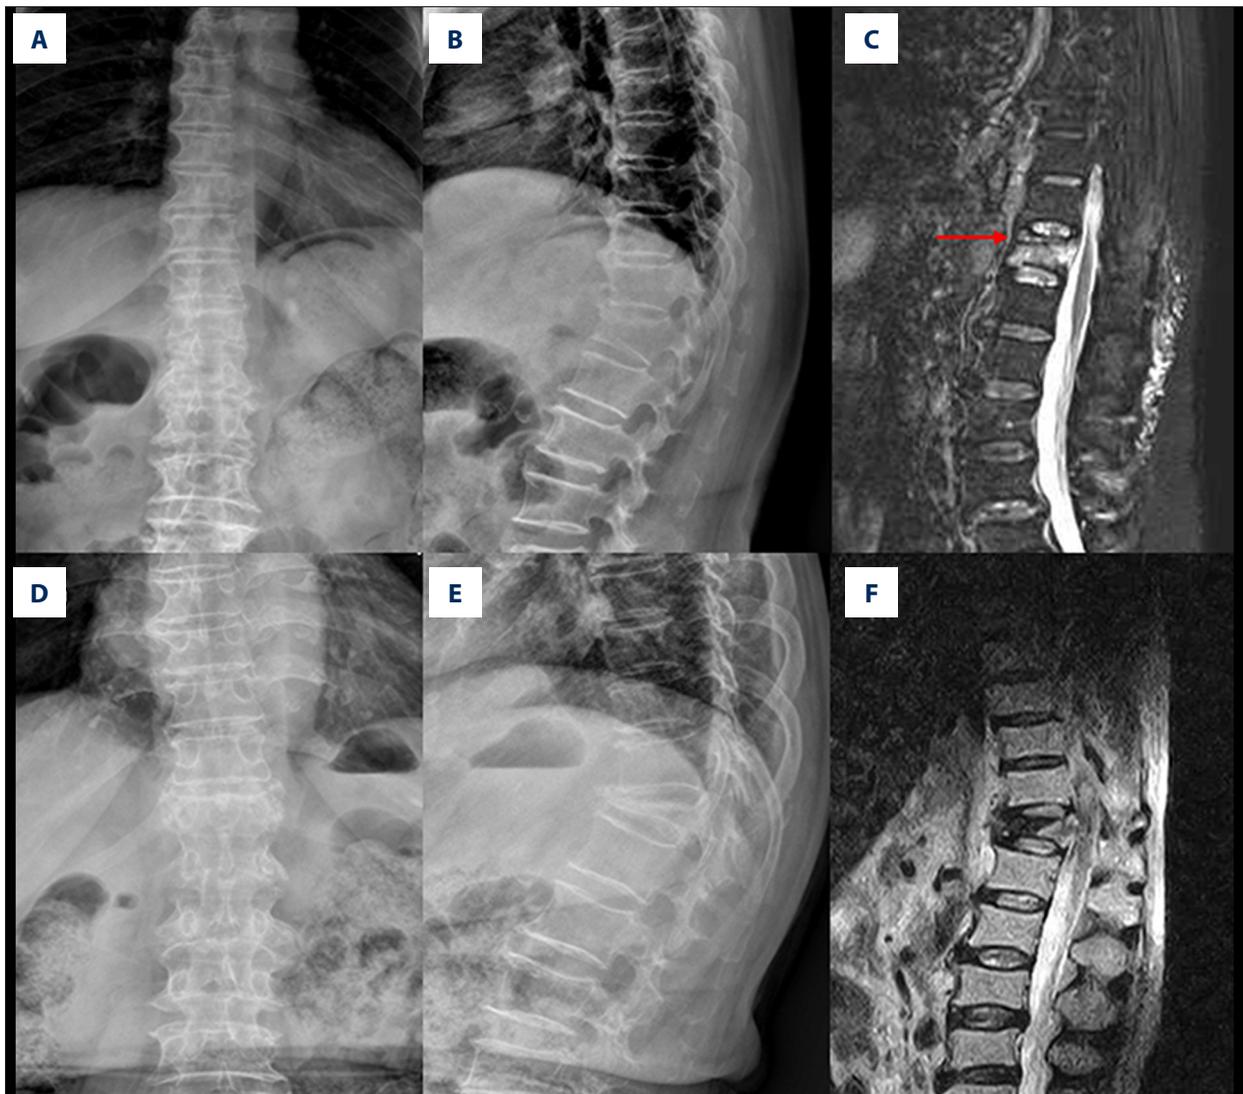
A 72-year-old female patient had a L1 osteoporotic vertebral compression fracture as a result of a fall. (A, B) X-ray showed L1 vertebral compression fracture. (C) A linear black signal was detected on MRI STIR sequence (red arrow). (D, E) At one-year follow-up, significant collapse of the L1 vertebral body could be seen on the anteroposterior and lateral views. (F) The L1 vertebral segment was collapsed, and intravertebral vacuum cleft was seen on MRI T2 sequence at one-year follow-up.
